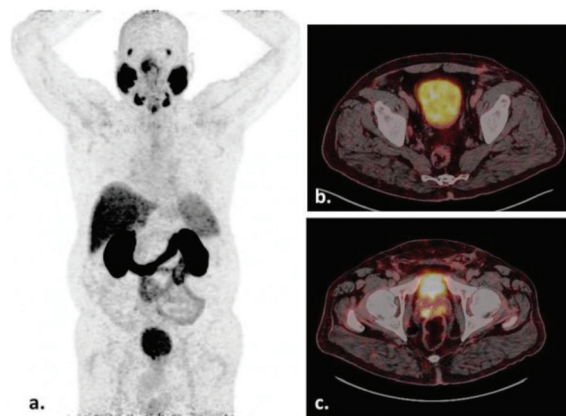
Ga-68 PSMA-11 positron emission tomography/computerized tomography imaging of 63 years old primary prostate cancer patient
